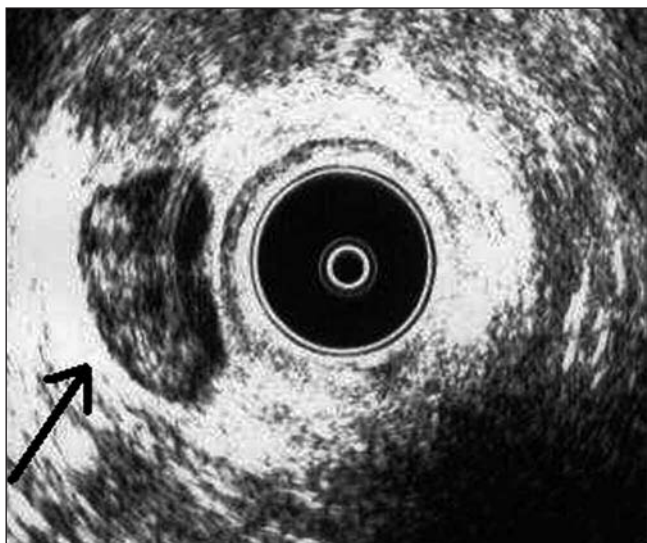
Endoanal ultrasonogram showing a 3-cm, hypoechoic, well-circumscribed mass with well-defined edges without infiltration of the external anal sphincter.
